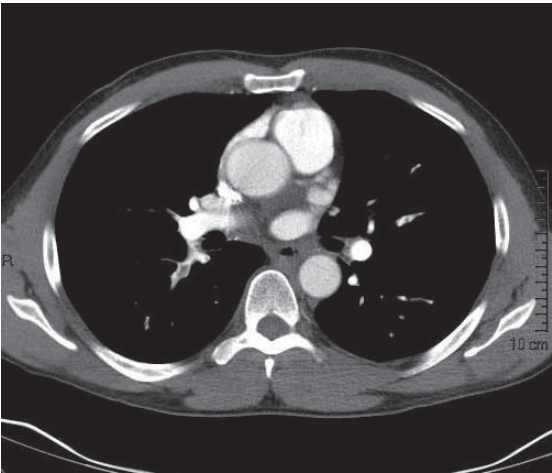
A CT scan of a pulmonary embolus. The arrow indicates the embolus in the right pulmonary artery.
